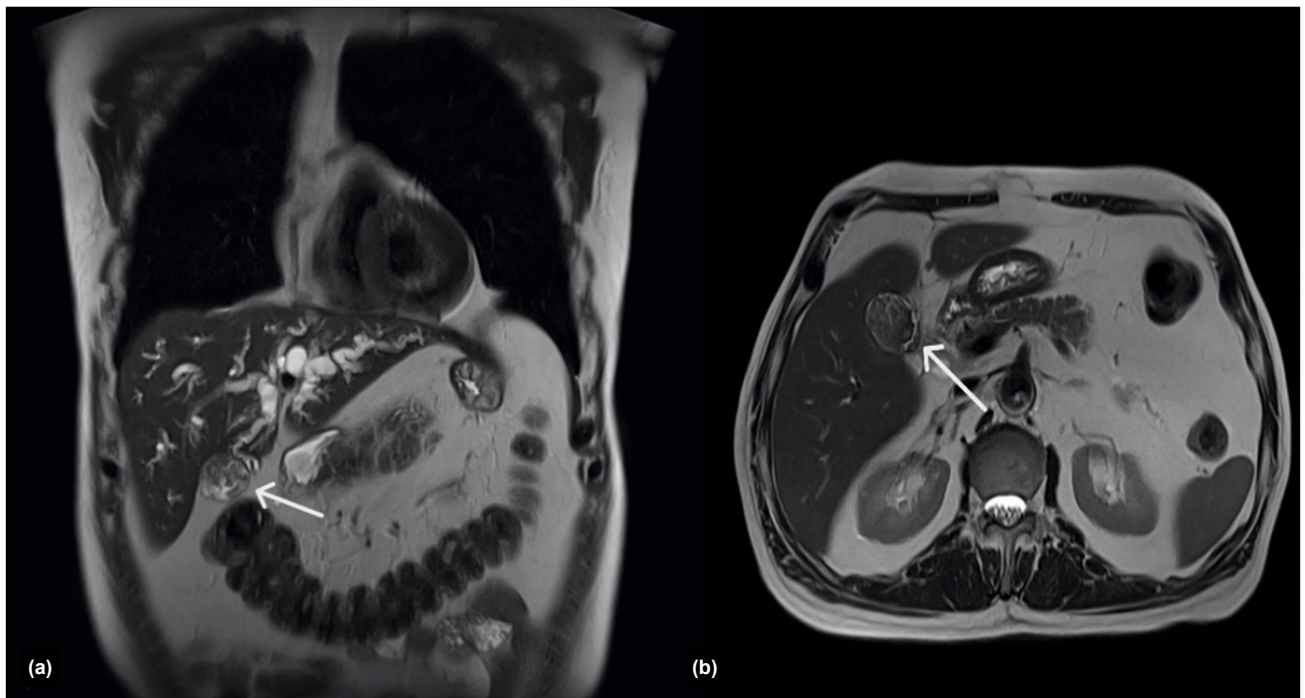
T2-weighted coronal (a) and axial (b) magnetic resonance images showing a 32×25 mm pseudotumoral lesion in the inferior part of the liver and dilatation of the intrahepatic bile ducts.
